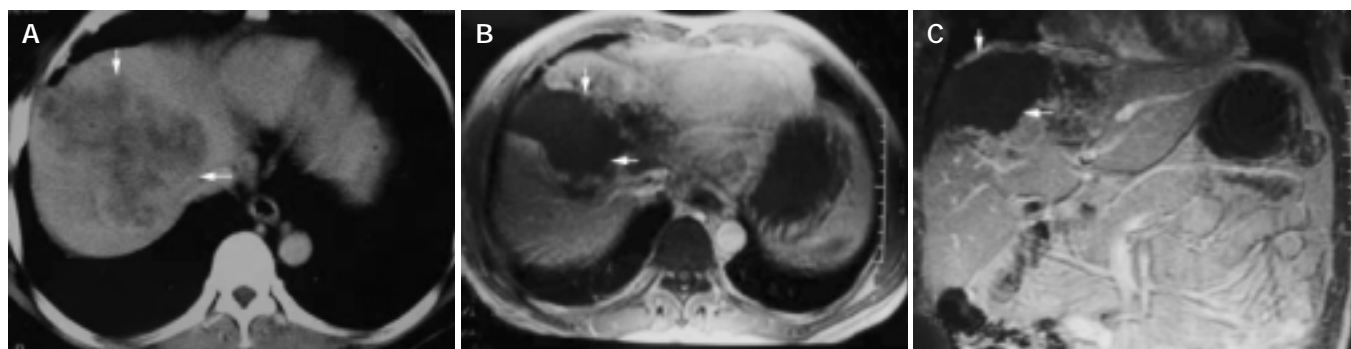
A 54-year-old man with primary carcinoma of liver in right lobe. A: CT enhanced imaging before HIFU treatment revealed that enhancement of mass in liver right-posterior lobe was higher than that of surrounding normal liver tissues (AFP: 5516 $\mu\text{g/L}$); B, C: MRI enhanced imaging (cross section and coronal section) 2 mo after HIFU revealed that necrotic tissue in the therapeutic region of the tumor was not enhanced (AFP: 183 $\mu\text{g/L}$).
